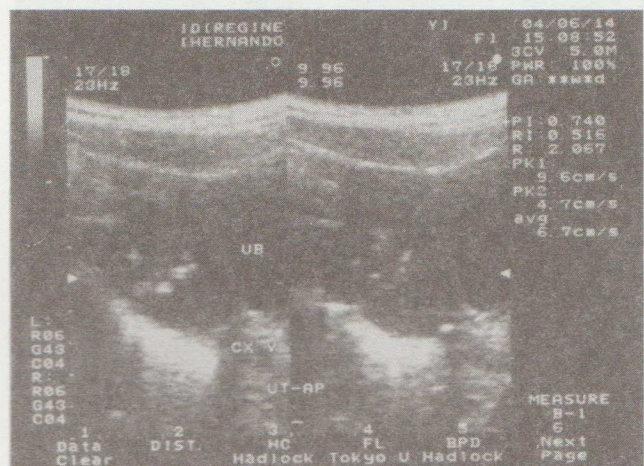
Transabdominal ultrasound anteroposterior view shows the characteristic of the vagina, cervix and uterus.
